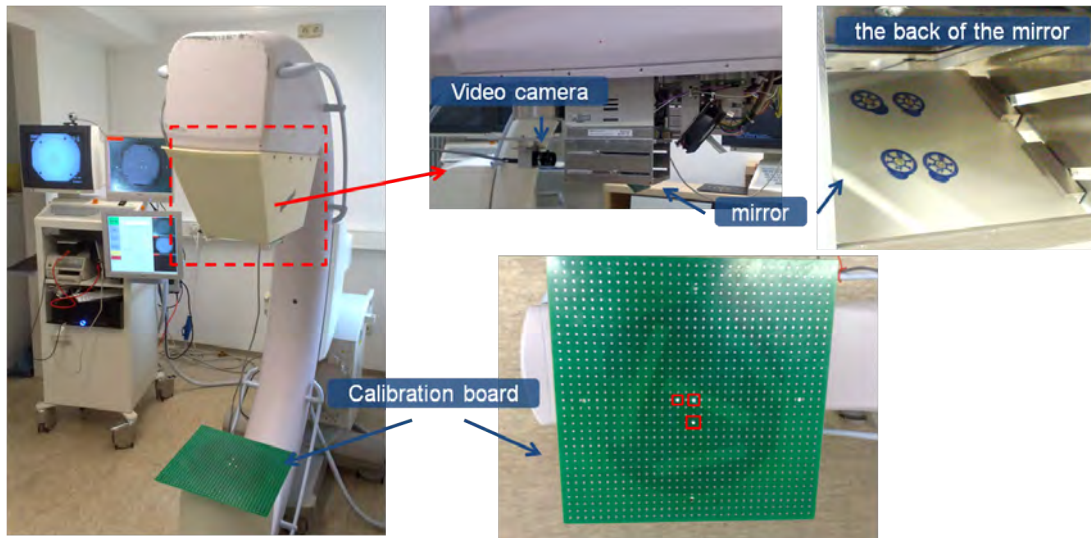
The experimental setup for analyzing the overlay accuracy of the CamC technology: The left image shows the CamC system. The top middle image shows the camera and mirror construction. The top right shows the four X-ray markers attached on the back of mirror for the virtual detector plane method. The left bottom image shows the employed calibration board with grid.
